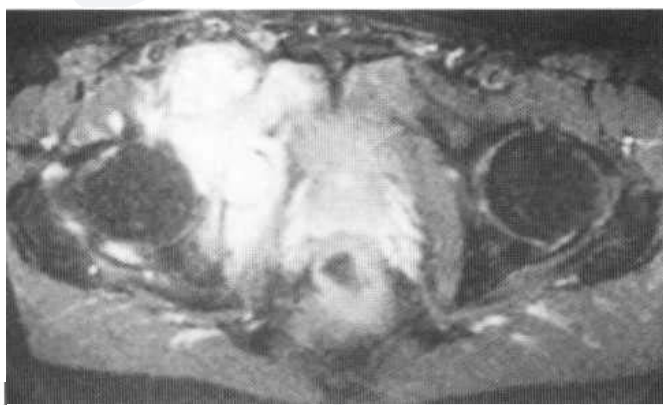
Chondrosarcoma arising in the acetabulum of a 45-year-old man. (A) The tumour is purely lytic. Cortical thickening is shown medially. (B) CT demonstrates disruption of the cortex posteriorly, with a localised soft-tissue mass beneath the glutei and faint calcification within the lesion.
